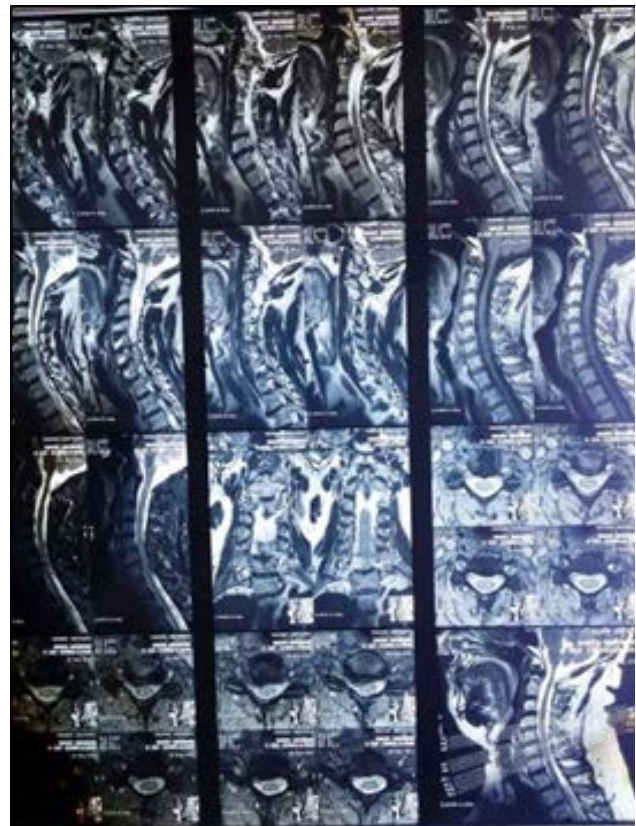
Cervical spine MRI (without colouring agent)
